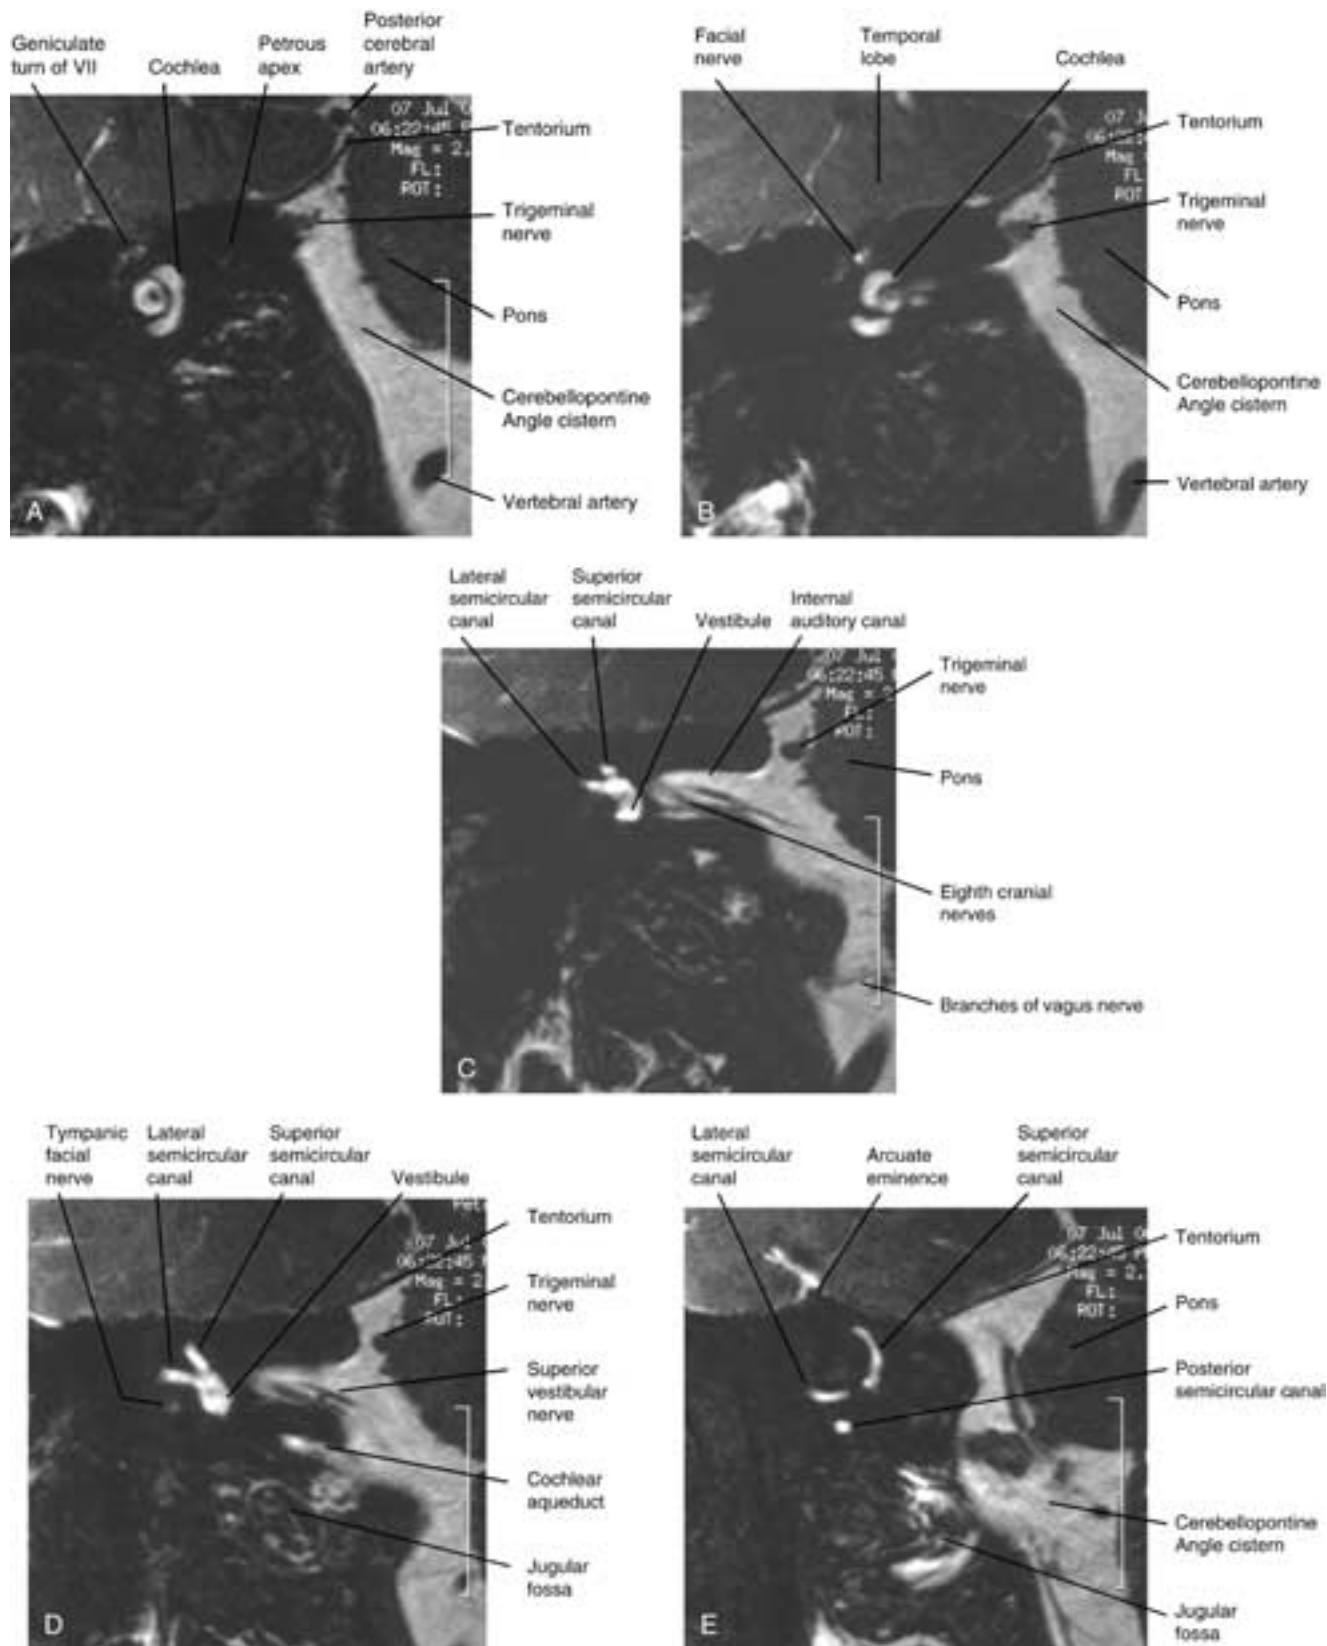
A to E, Coronal MR imaging from anterior to posterior. As in [Figure 20-13](#), the fluid spaces are visualized as high signal. Nerves are seen crossing the bright signal of the CSF within the IAC.
